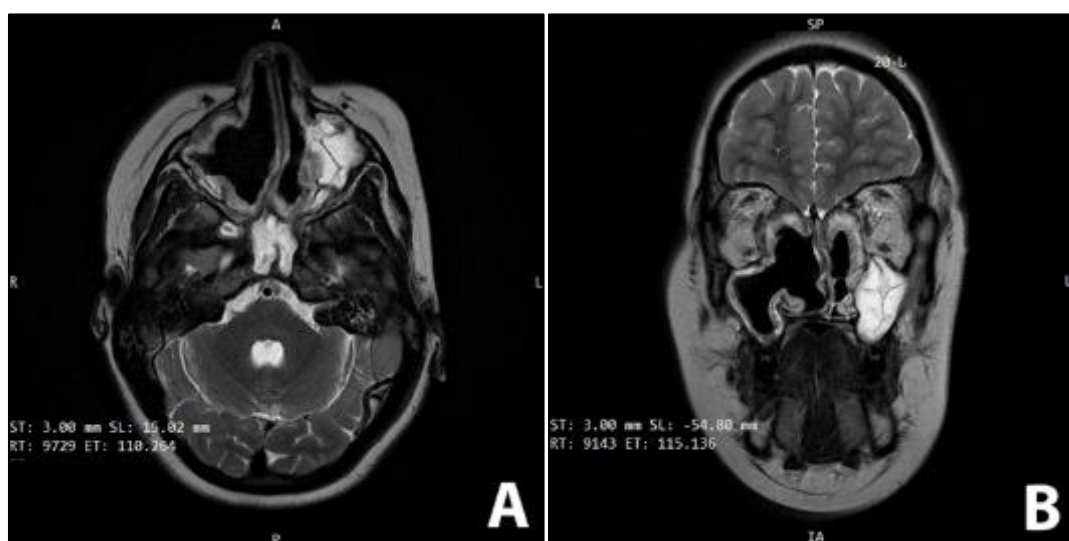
MRI 6-Month Control; A: Axial Cuts showing post-surgical status with no signs of recurrence.; B: Coronal Cuts highlighting the resolution of the mass and the condition of the surrounding structures
